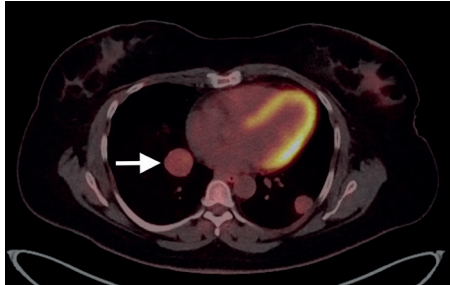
18FDG positron emission tomography-computed tomography showed that the lung lesions were FDG avid, for example the largest lesion within the right lower lobe (arrow) had standardized uptake values (SUV)-max of 4.9. Aside from the pulmonary nodules no other site of abnormal uptake was identified.
